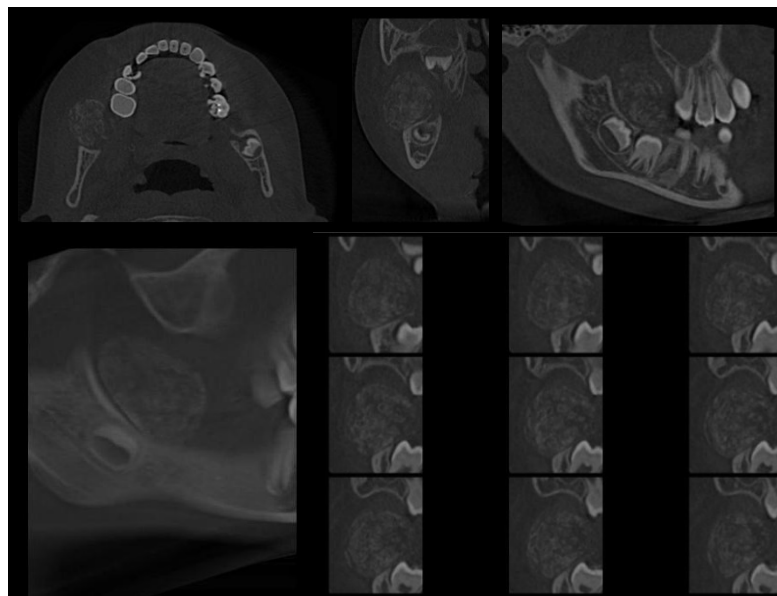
CBCT showing mixed lesion with pedunculated appearance in the right retromolar trigone region.
